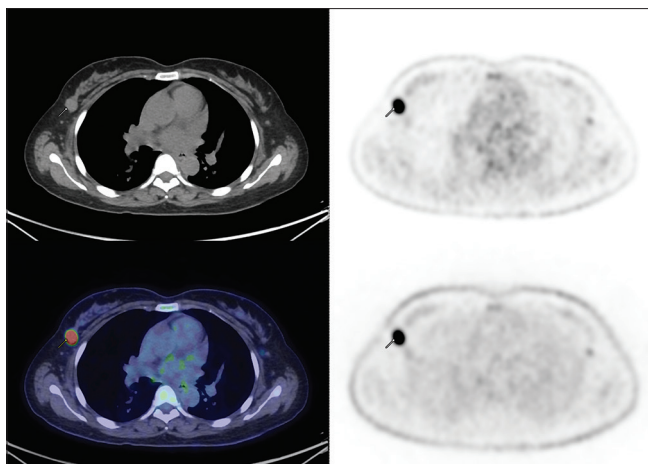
A hypermetabolic circumscribed oval nodule (SUV_{max} 14.9, 16 mm) at the upper outer quadrant of the right breast was detected, which raised concern for breast malignancy. Biopsy was performed and showed lymphoid hyperplasia with the presence of melanin, confirming a right intramammary node with features of dermatopathic lymphadenitis
